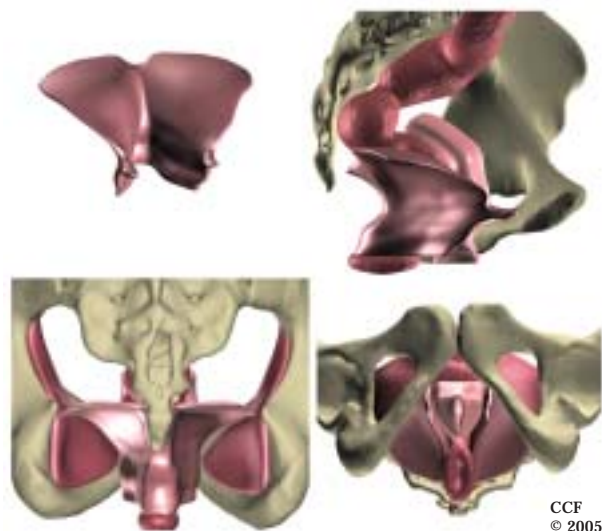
Digitally enhanced three-dimensional reconstructions of the female pelvic floor from a magnetic resonance image of the pelvis in a normal nulliparous 23-year-old woman. Upper left: anterior view of the levator ani muscle with normal resting tone. Upper right: sagittal view of the levator ani muscle, bony pelvis, vagina, and rectum. Lower left: posterior view of the levator ani muscle, obturator internus muscles, and bony pelvis. Lower right: lithotomy view.
